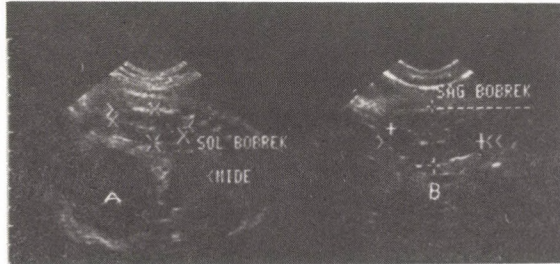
Antenatal ultrasound scan shows, A: left ovarian cyst and B: multicystic dysplasia of right kidney
